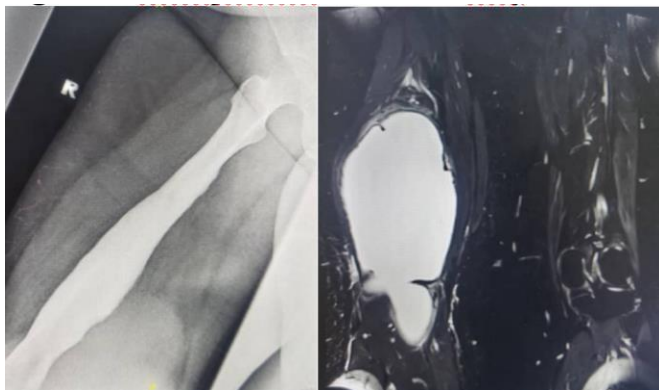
PreOperative MRI and xray
